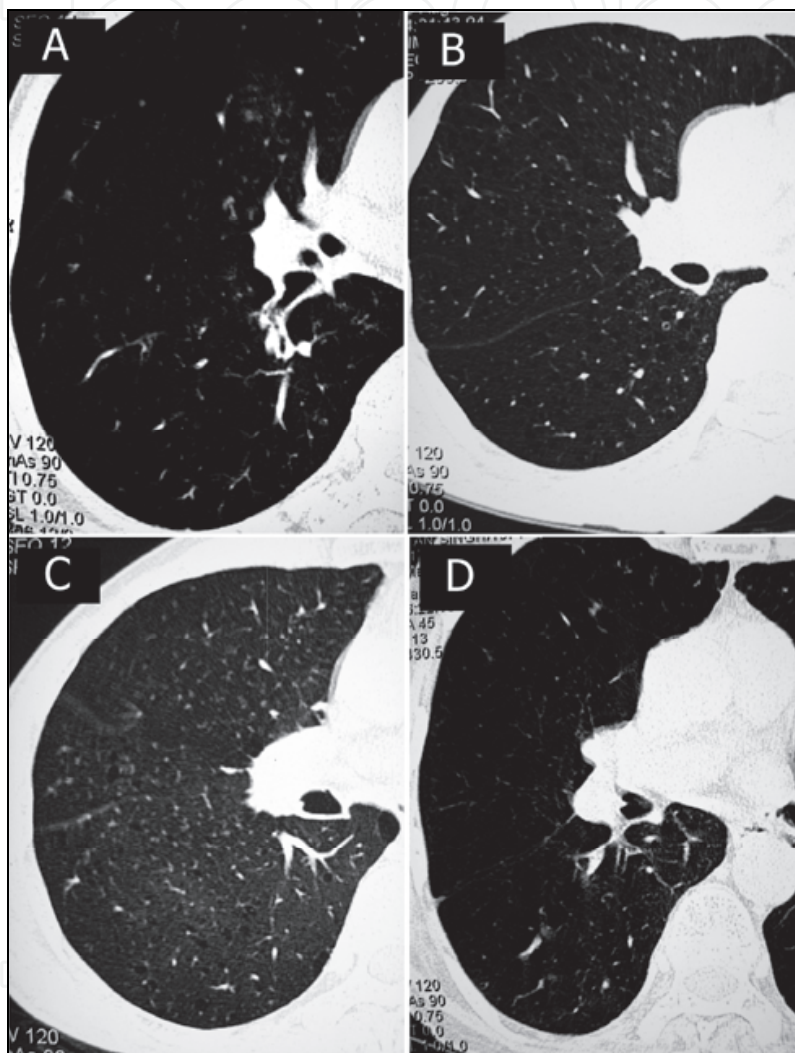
(A-D) : HRCT scans of different COPD patients showing vascular attenuation characterized by thinning of pulmonary vessels at the peripheral lung field along with reduction in their number.
